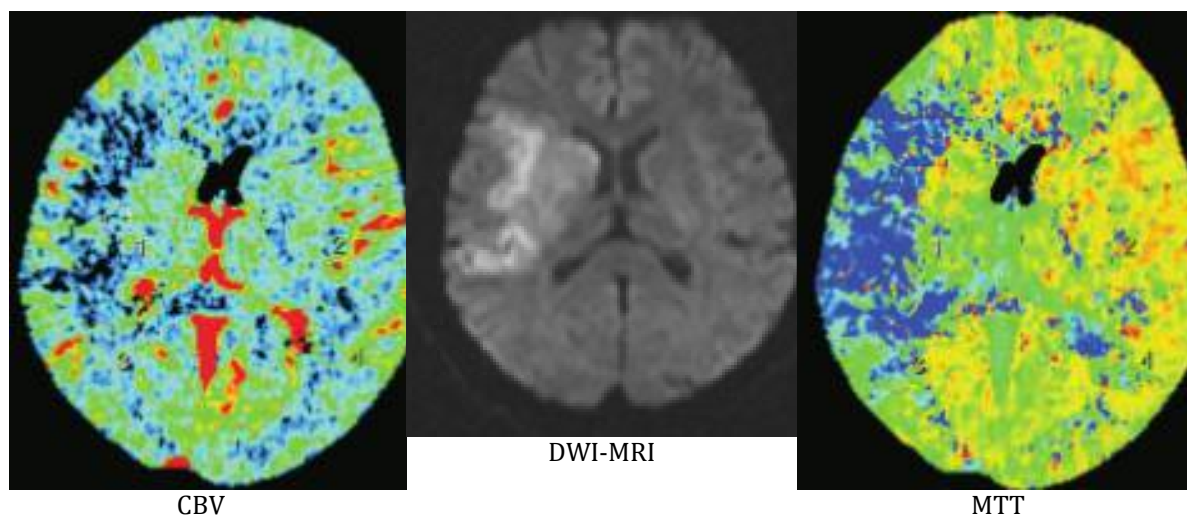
Presence of areas of mismatch of the size of the focus on DWI-MRI with the areas of perfusion cards CBV, CBF and MTT
